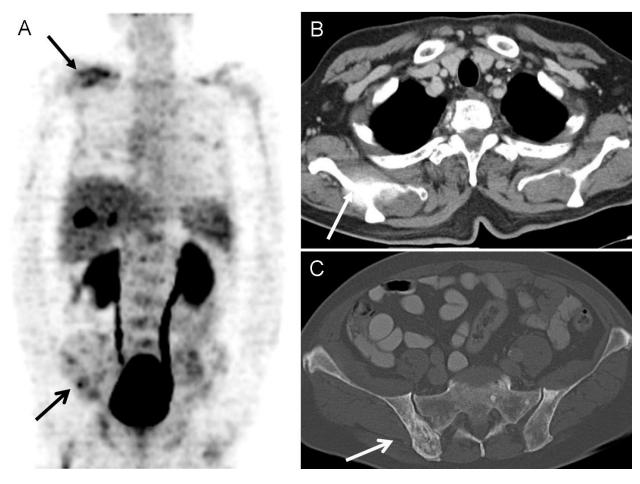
Patient with diffuse osseous metastases from prostate carcinoma. The maximum intensity projection (MIP) of the [¹⁸F]Galacto-RGD PET scan shows focal and diffuse tracer uptake in the whole skeleton, most intense in the right scapula (arrow, closed tip) and in the pelvis (arrow, open tip). Note, the tracer accumulation in the urogenital tract due to predominantly renal tracer elimination, and to a lesser extent in the gallbladder, liver and spleen. Only low tracer uptake is notable in the residual organs and background. The corresponding CT scan shows the osseous metastasis in the scapula (B) and in the pelvis (C).
